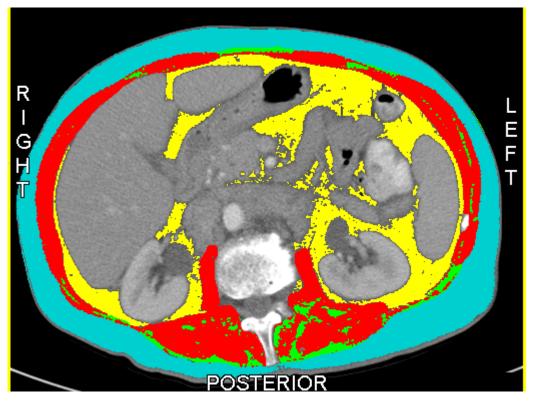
Body composition analysis using CT imaging at the L3 levelRed = Skeletal muscle tissue.Green = Intramuscular adipose tissueBlue = Subcutaneous adipose tissue.Yellow = Visceral adipose tissue.
